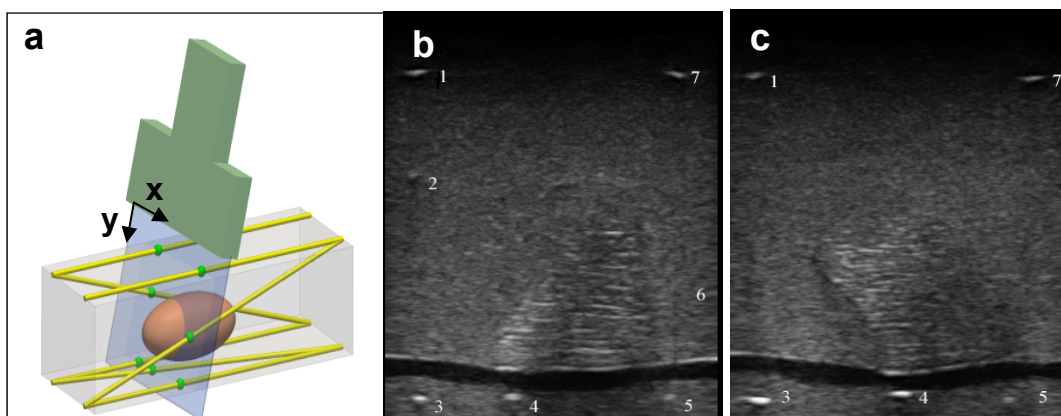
Ultrasound imaging setup (a) and sample images (b, c). The left ultrasound image (b) is typical of the data we used. The right image (c) is an example of an infrequent case where the side fiducials are visible. The leftmost image is a more typical case in which the side fiducials are not visible.
